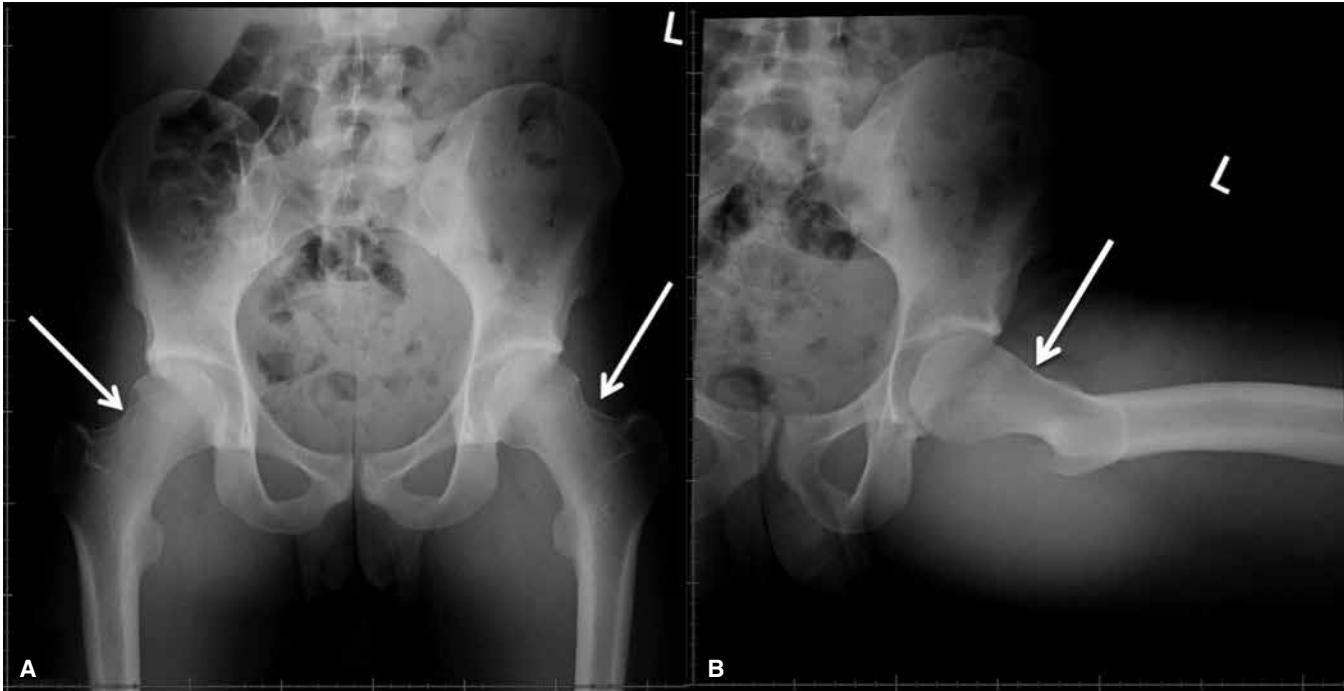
(A) Supine AP pelvis radiograph of 19-year-old male patient that appear to reveal no FAI or abnormal morphology of either femoral head and neck. (B) Lateral Dunn radiograph of the same 19-year-old male patient revealing anterosuperior cam morphology and FAI of the left hip.
